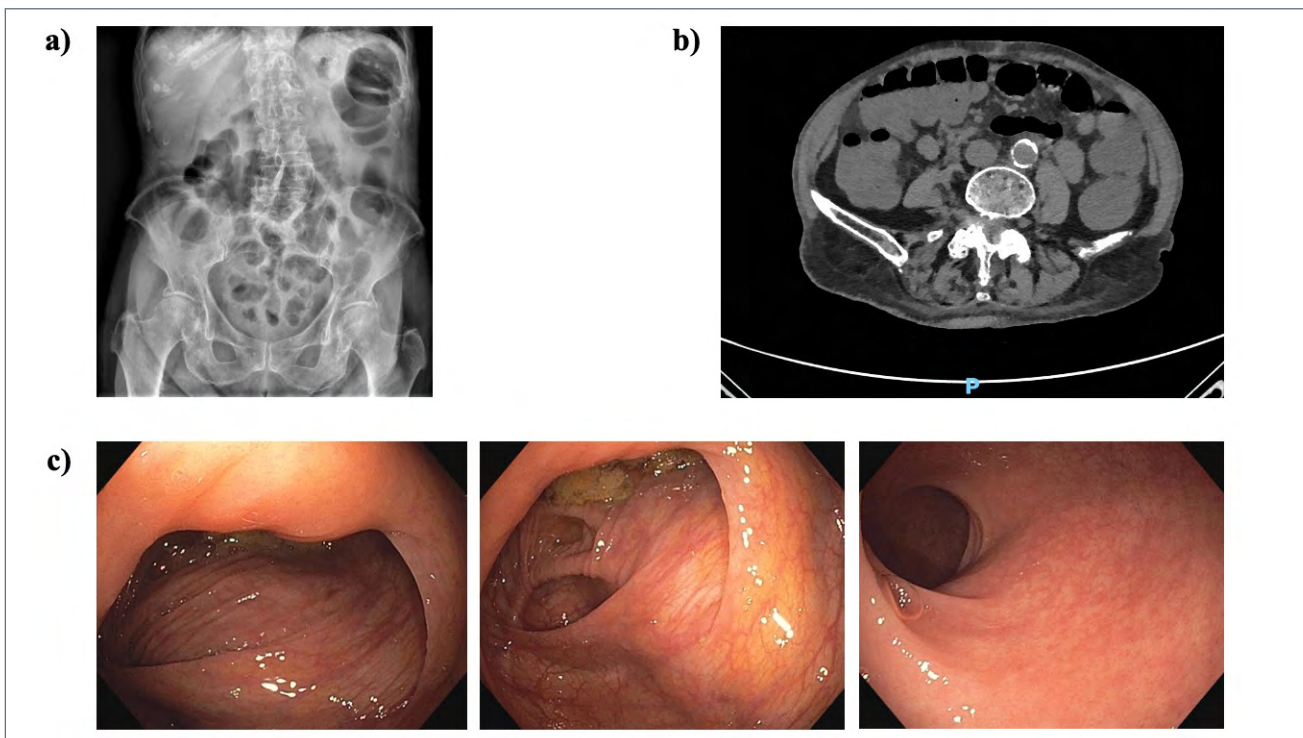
Abdominal X-Ray (A), CT scan (B) and colonoscopy (C).
